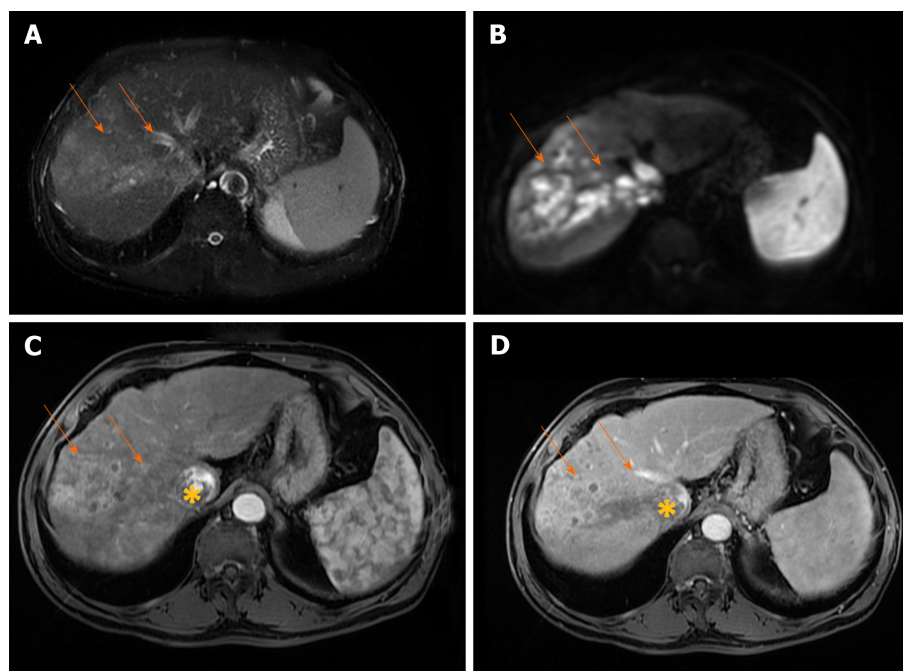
Infiltrative hepatocellular carcinoma in 71-year old man with cirrhosis. A: Axial T2-weighted FS image shows ill-defined mass (arrows) in segments VII and VIII; B: On diffusion weighted image the lesion is hyperintense; C and D: The tumor is heterogeneously hyperintense on arterial phase (C), with washout in portal vein phase (D). Note also right hepatic vein thrombosis with propagation of the tumor thrombus in vena cava inferior (asterix).
